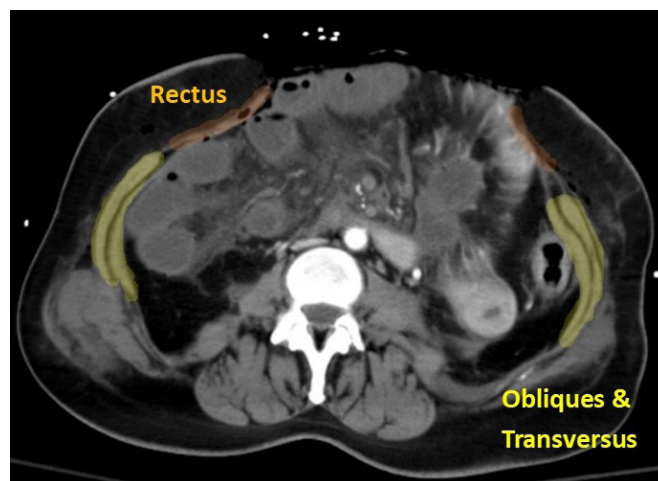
Axial CT with abdominal wall labeled. Oblique and transversus abdominus muscles labeled in yellow showing retraction. Rectus abdominis muscles labeled in orange with disruption of the right and the left severely damaged.
